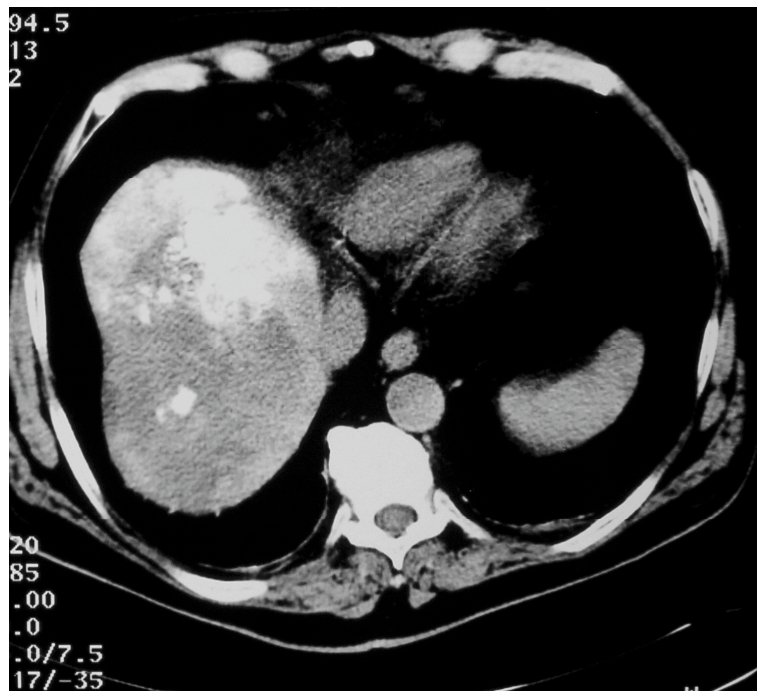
CT showing tumor regrowth, extending almost to the entire liver parenchyma.
